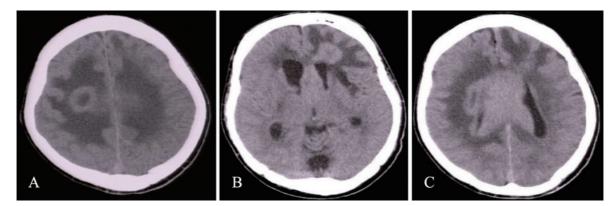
Preoperative brain computed tomography scans at approximately 1 month after symptom onset. The tumors were accompanied by marked edema (A, B), were located in both hemispheres, and were centered on the corpus callosum (C).
